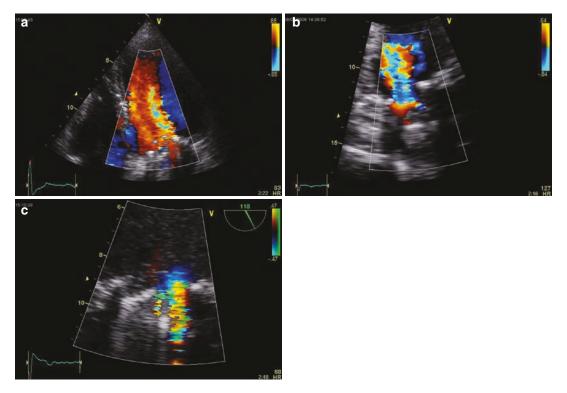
Obstructed bileaflet mechanical valve. These are apical 4-chamber transthoracic image with colour Doppler showing a normal valve (a) and an obstructed
